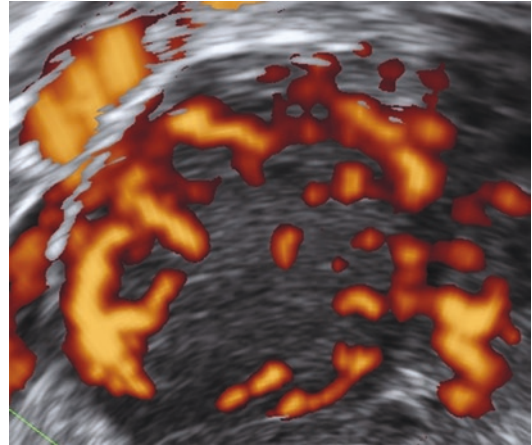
Power Doppler demonstrating abundant vascularity in a solid malignant ovarian tumor
